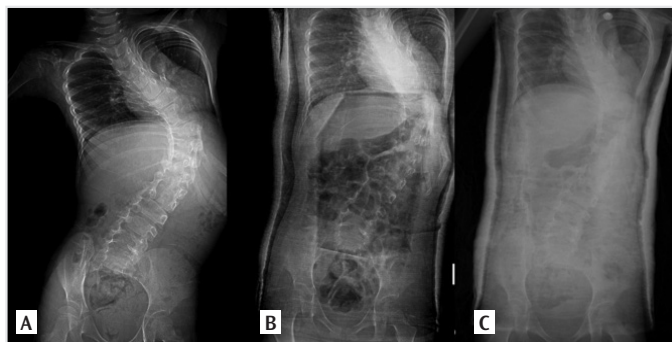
A) Twenty-eight month-old girl congenital scoliosis pre-casting posteroanterior radiography, B) after initial cast application, C) at five cast application
